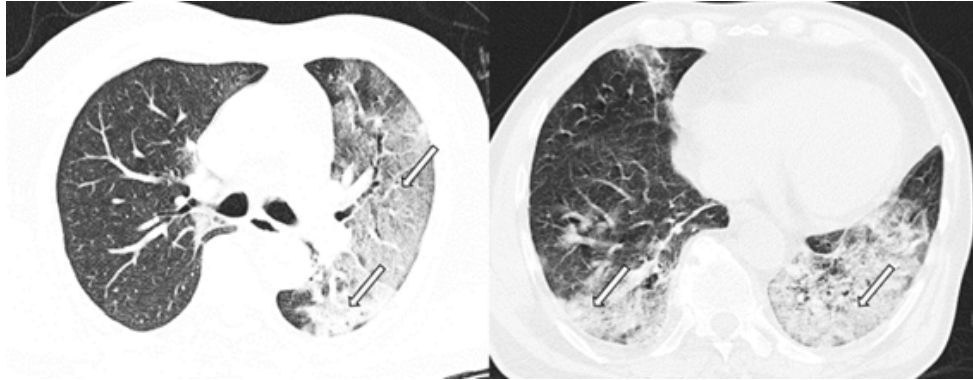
Chest CT scan shows bilateral ground-glass opacities with superimposed interlobular septal thickening and visible intralobular lines (“crazy-paving”) and consolidations.
